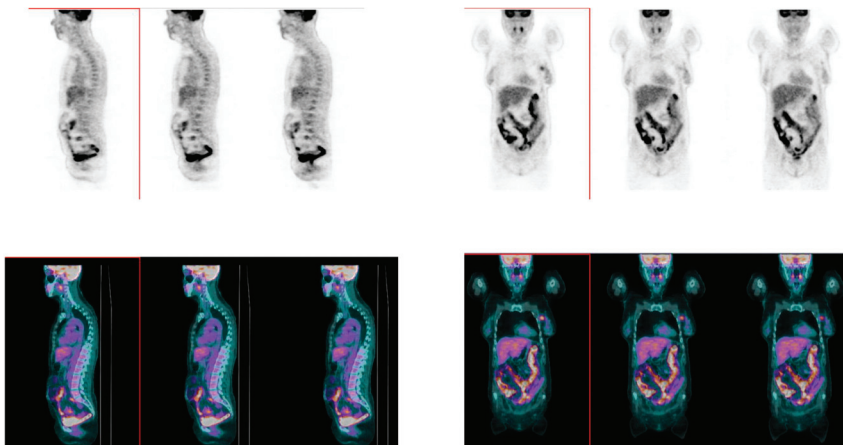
Sagittal (left panel) and coronal (right panel) images of whole-body [18]F-FDG PET/CT scan. PET (upper panels) and fused PET/CT (lower panels) images, showing diffuse nonhomogeneous [18]F-FDG uptake in colon and rectum in a BC patient who did not reach pCR.
